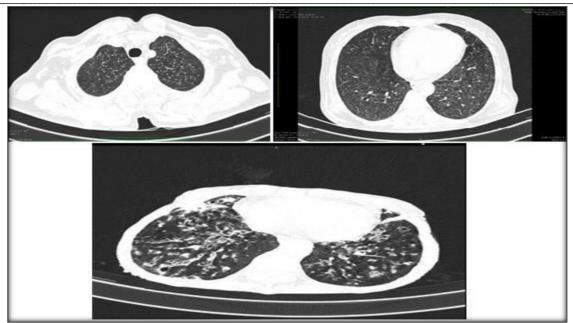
Photographs in study. A. Axial HRCT Image Lung Window, B. HRCT Images showing Miliary mottling in bilateral lung field, A 65 Year old female Complaining of Cough, Evening rise of Temperature since 2 months. Her HRCT Images HRCT Images showing Cavity with adjacent Parenchymal bands in the Right Upper lobe, nodules in the left Upper lobe. Changes of consolidation in Right Middle lobe; Cystic bronchiectasis with peribronchial thickening in bilateral middle & lower lobes.
